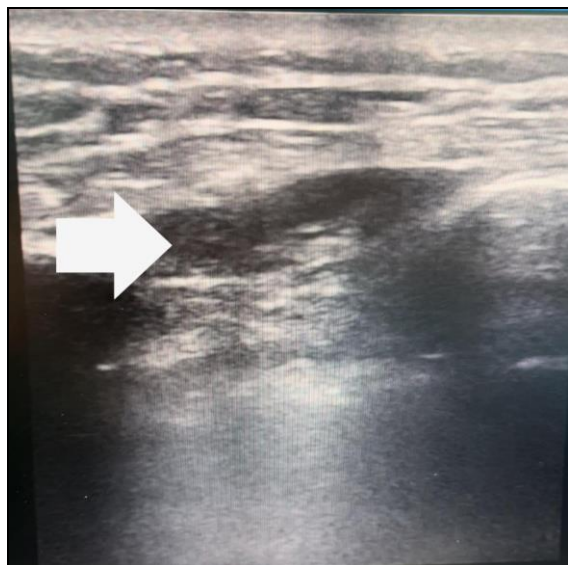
PRS Block Ultrasound Image.
